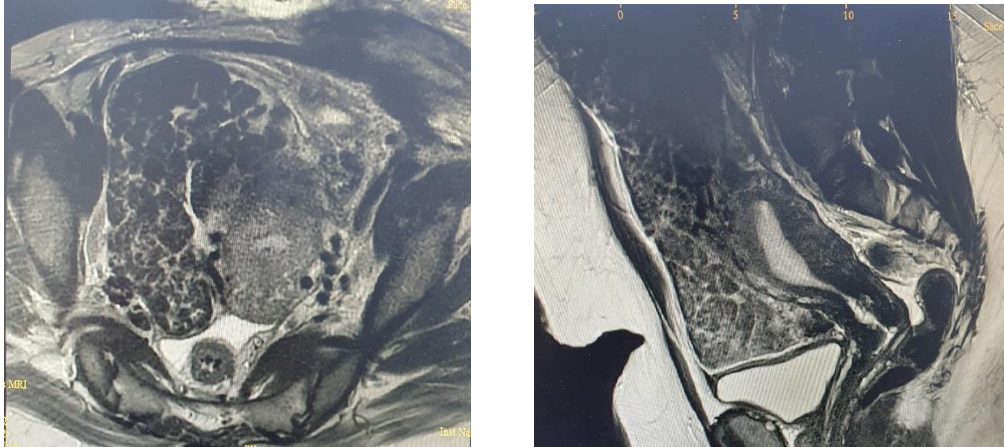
MRI abdomen with gadolinium.
